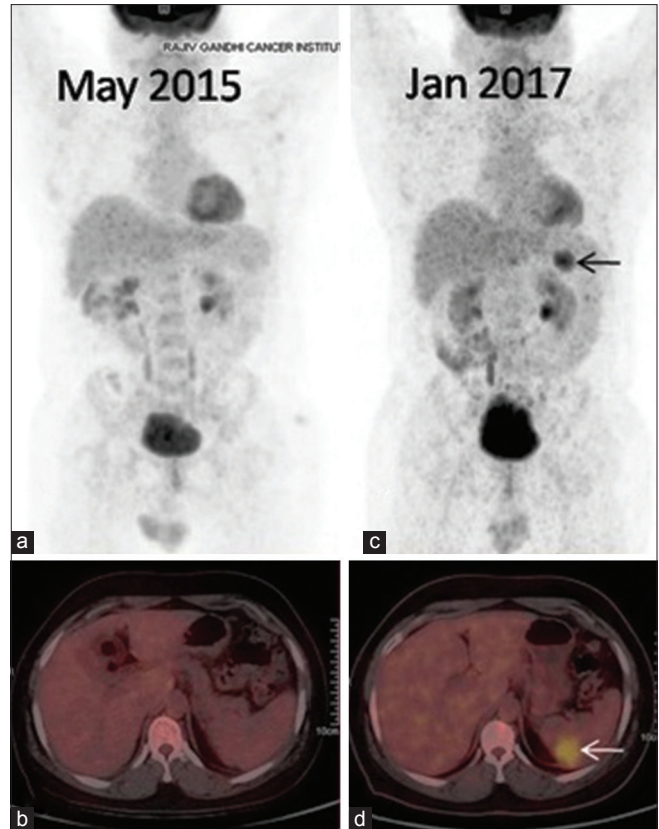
Maximum intensity projection (a and c) and axial (b and d) positron emission tomography-computed tomography images depicting focal fluorodeoxyglucose avid splenic lesion (arrow) in follow-up study
